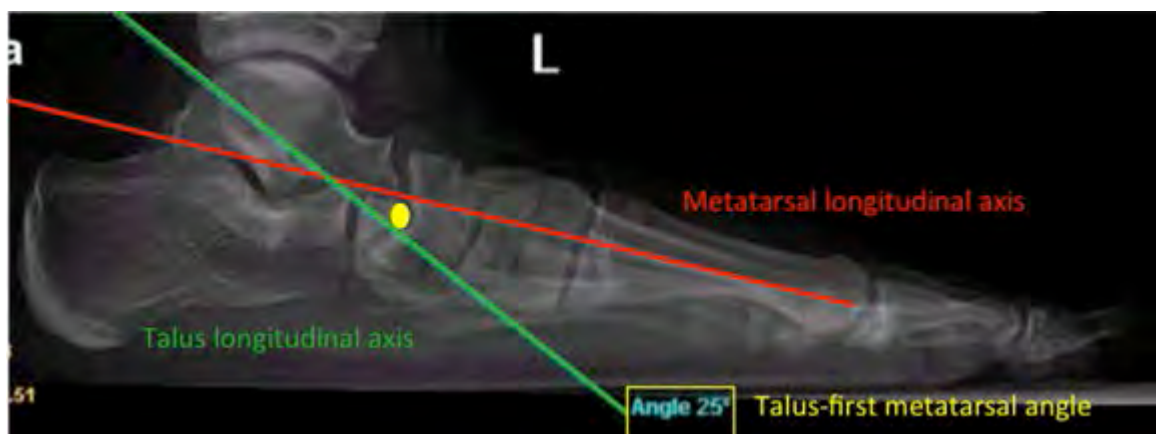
Radiograph showing axes used and angle measured for TFMT Angle (Villarroya, 2008).
